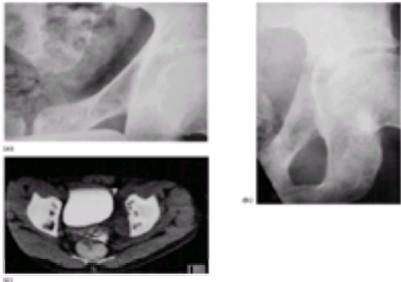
(a) The initial radiograph shows early displacement of the fat pad over obturator internus. (b) Subsequent images of this region, including a CT scan (c), show progressive enlargement of this soft tissue mass with destruction of the overlying bone due to a reticulum cell sarcoma.
